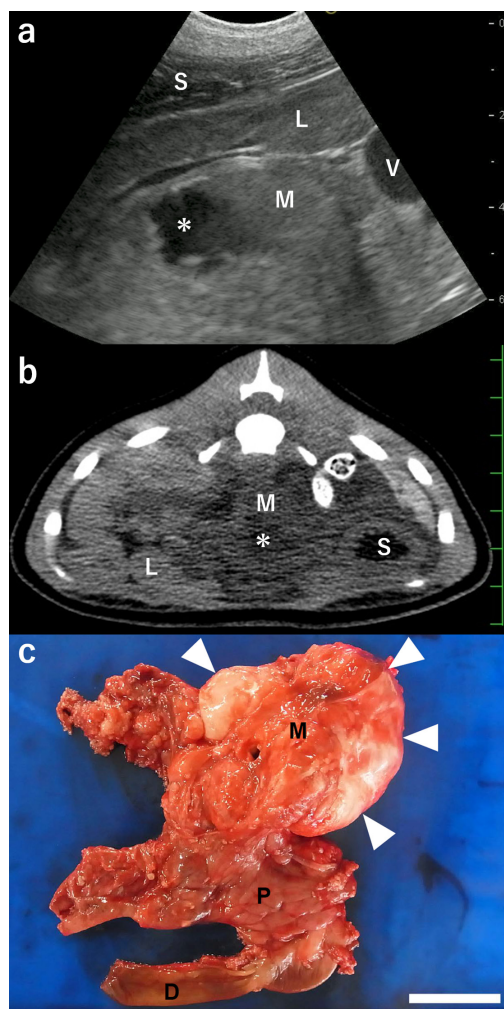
Ultrasonogram (a), computed tomographic image (b), and macroscopic view (c) of the mass lesion (M) in the pancreas. (a) An echogenic mass (M) is seen at sites deeper than the skin, subcutaneous tissues (S), liver (L), and large blood vessels (V). The mass includes a hypoechoic cavity (asterisk) in the center. (b) A mass (M) is seen in the space between the stomach (S) and liver (L), and it features a low-density lumen (asterisk) in the center. Scale=25 mm. (c) A whitish, round mass (arrowheads) is seen to protrude from the pancreas (P). D, duodenum. Bar=5 cm.
